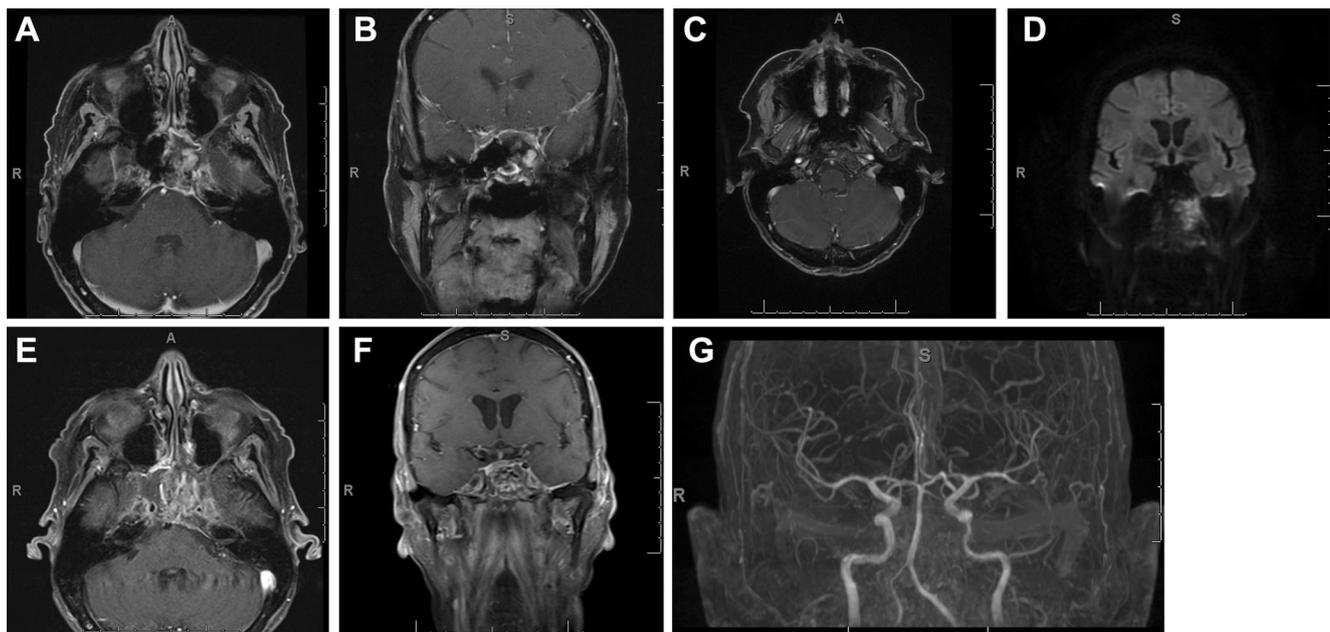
Preoperative magnetic resonance imaging (MRI) with gadolinium contrast of the brain. a Axial and b coronal T1-weighted MR images at presentation demonstrating heterogeneously enhancing lesion in the sphenoid sinus involving the right petrous apex and upper clivus, as well as linear enhancement of the petrous and clival dura. c T1-weighted axial MR image and d coronal diffusion-weighted image performed 1 week after the patient started on antibiotics demonstrating
